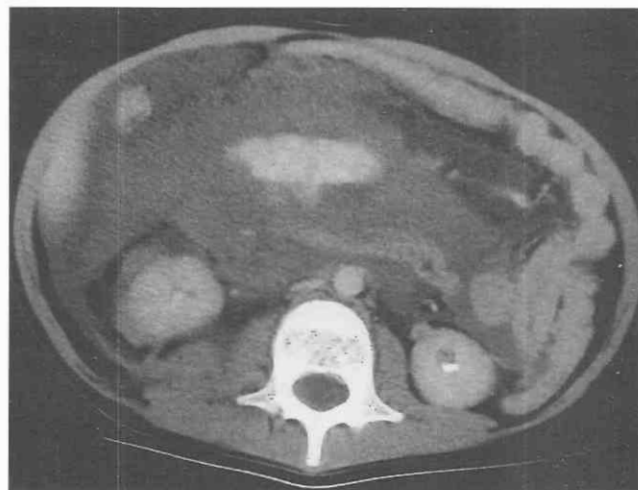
Active hemorrhage. CT scan through the midabdomen demonstrates a focal area of high-attenuation fluid representing active hemorrhage from a torn mesenteric vessel. The surrounding intermediate-attenuation clotted blood can be seen.
